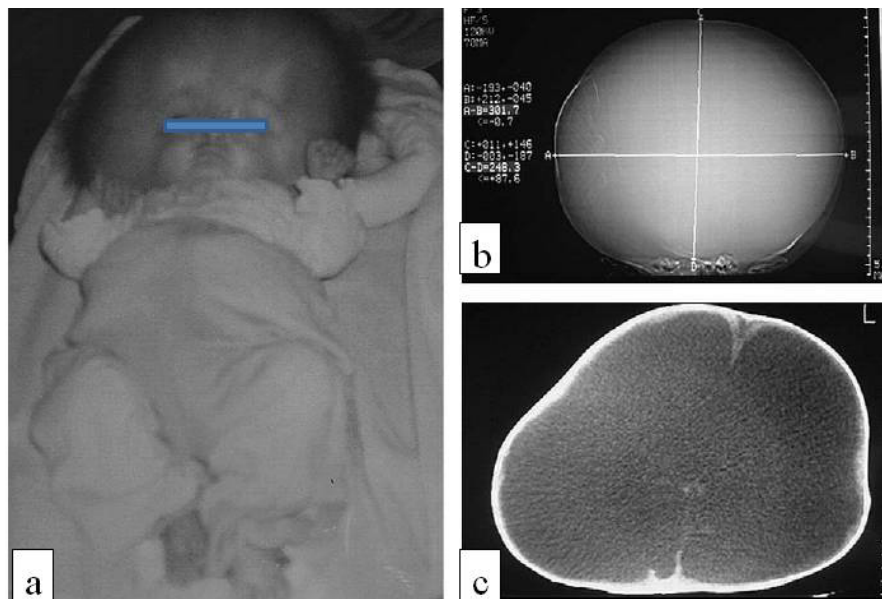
Appearance of a hydrocephalic infant and its CT images. a) The head circumference is nearly 70cm at the age of 3 months, b) CT scan has estimated the coronal (AB) and sagittal (CD) diameters of enlarged skull as 301.7 and 248.3mm, respectively, c) severe atrophy of cerebral parenchyma and huge ventriculomegaly [11].
